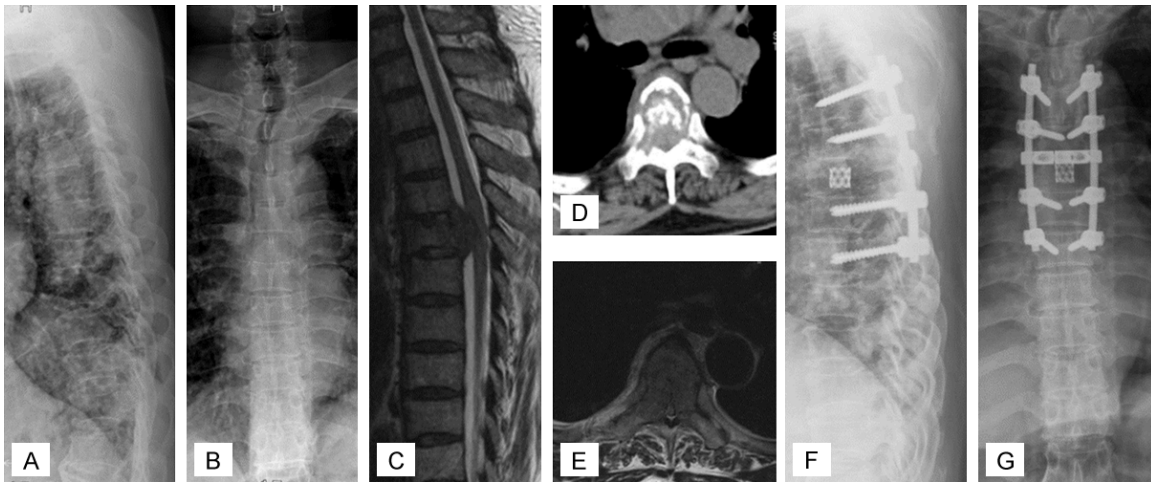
A 67-year-old man who unable to walk due to metastatic epidural spinal cord compression (MESCC) resulted from prostate cancer. A and B. Preoperative X-ray presented vertebral collapse at T5. C. Preoperative MRI showed spinal cord compression at T5. D. Preoperative CT showed bone destruction at T5. E. Preoperative MRI showed spinal cord compression at T5. F and G. Following laminectomy at T4 and T5, and pedicle screw fixation was conducted at T3, T4, T6, and T7 to spine stabilization. He died at postoperative 9.2 months and spine stability was maintained throughout the survival period.
